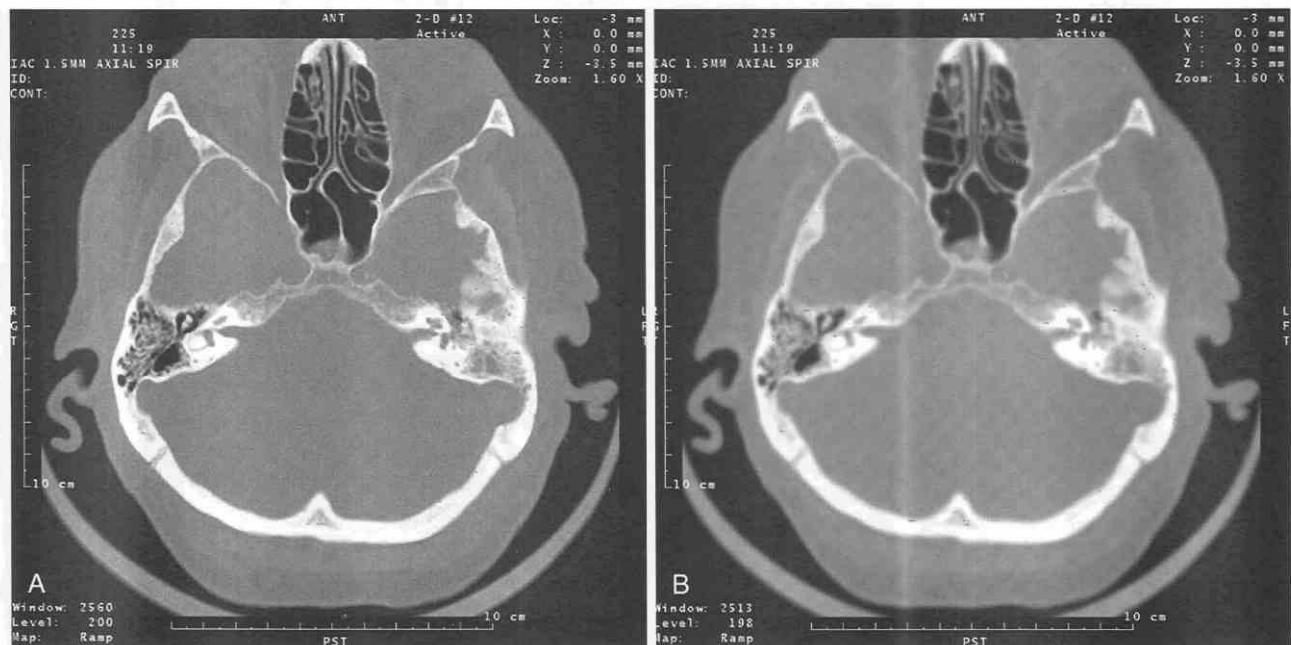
Filter effects on CT images. *A*, Image with high-frequency filter. Note the sharp image appearance and enhanced edge detail. *B*, Image with low-frequency (smoothing) filter. Note the blurry effects and decreased image sharpness. This filter increases density resolution at the expense of spatial resolution. (*A* and *B*, Courtesy of Marconi Medical Systems.)
